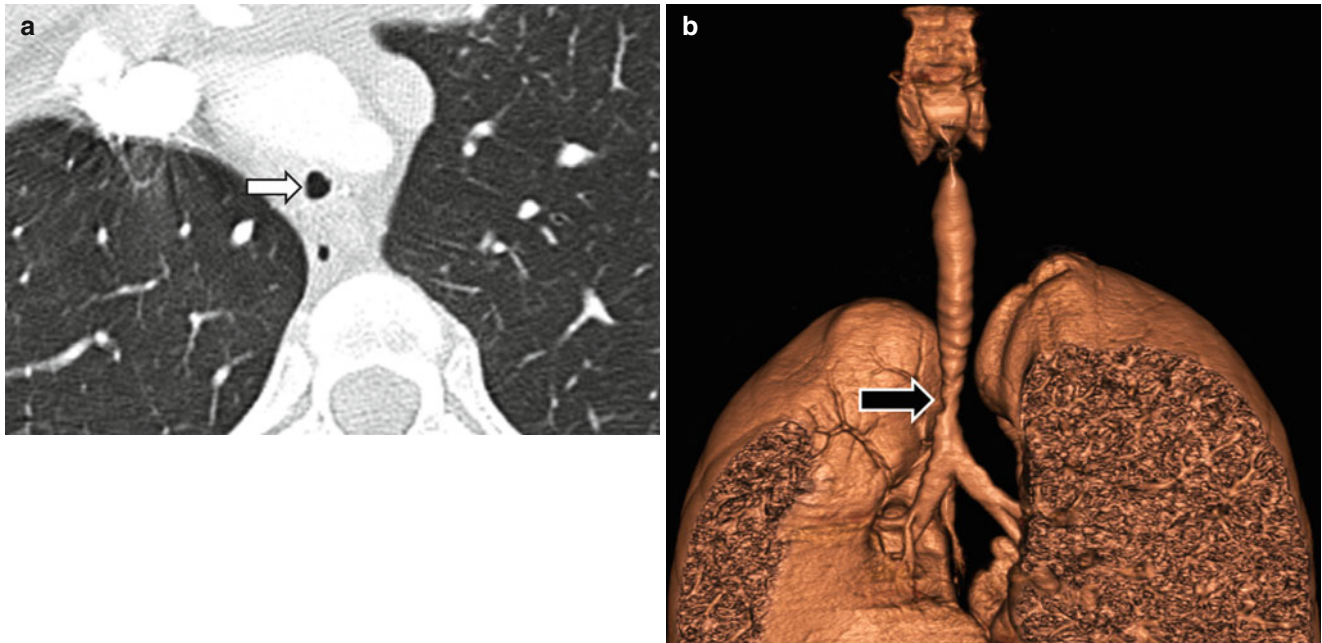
Focal congenital tracheal stenosis in a 14-year-old girl who presented with stridor and wheezing. (a) Axial CT shows a narrowed trachea (*arrow*). (b) Three-dimensional volume-rendered image shows a high-grade short-segment tracheal stenosis (*arrow*)
